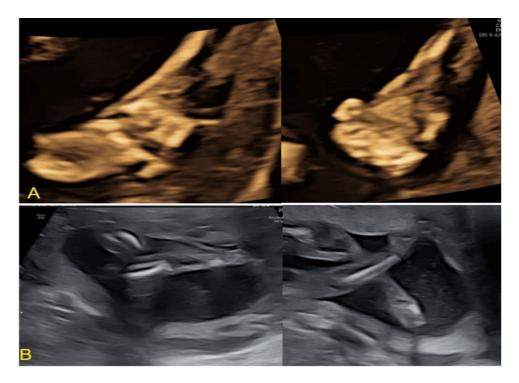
Ultrasound of fetus showing bilateral clubfoot. No polydactyly was noted
